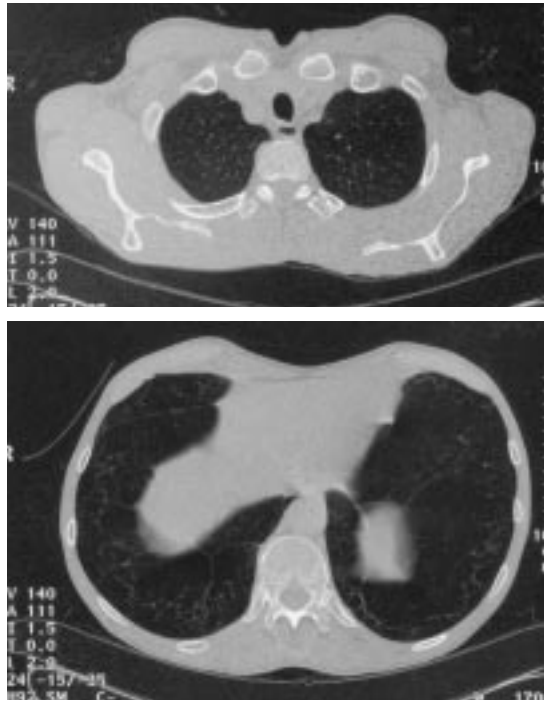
Computed tomographic scans of the chest. Both show emphysematous change manifested by the loss of parenchymal markings, which is more pronounced in the base of the lung (bottom) than in a more cephalad cut (top).
